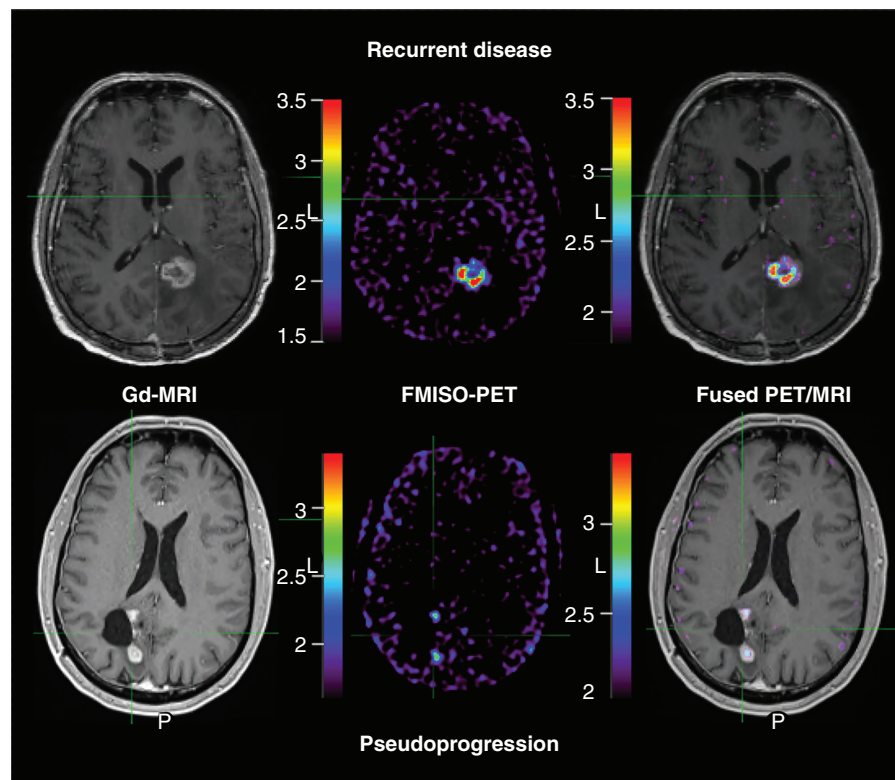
FMISO PET MRI at the time of glioblastoma presumed disease progression. Gadolinium-enhanced MRI (Gd-MRI; left) at the time of presumed disease progression in patients treated with Stupp protocol with concurrent pembrolizumab demonstrates similar appearing contrast-enhancing mass in patients with both recurrent tumor growth (top) and neuroinflammatory-based therapeutic changes; pseudoprogession (PSP, below). Unlike recurrent disease, patients with PSP demonstrated minimal hypoxic volume (middle column) and hypoxic fraction (right column; ratio of hypoxic volume to gadolinium-enhancing volume). In this example, the patient with recurrent disease demonstrated a hypoxic disease burden of 178%. Conversely, the example of PSP demonstrated a hypoxic fraction of 24%. Note: FMISO PET image (middle) window minimum is the mean cerebellar background and window maximum is 2× the mean cerebellar background. Fused PET/MRI image (right) window is the hypoxic volume of 1.2× the mean cerebellar background and window maximum is 2× the hypoxic volume SUV. PET intensity color scales represent the respective visualized SUV measures. Abbreviations: FMISO, [¹⁸F]-fluoromisonidazole; MRI, magnetic resonance imaging; PET, positron emission tomography; SUV, standard uptake values.
